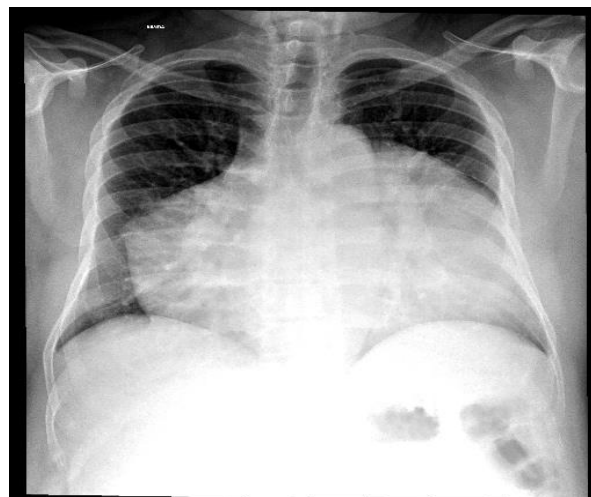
PA chest x-ray. Presence of increased mediastinal area.
